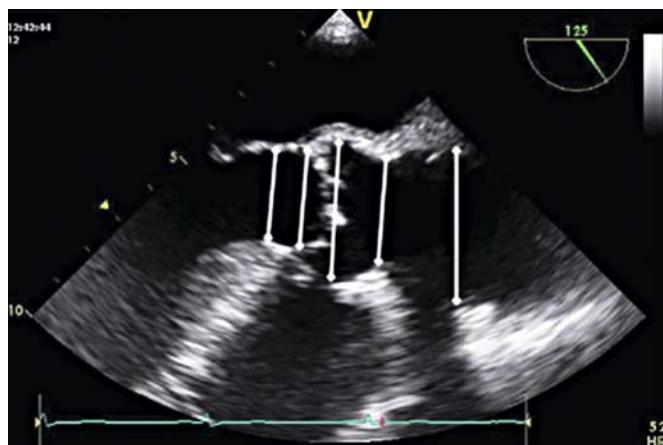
Intraoperative transesophageal echocardiographic measurements of the aortic valve annulus, including the diameter of the left ventricular outflow tract (to exclude severe asymmetric septal hypertrophy), aortic valve annulus, sinuses of Valsalva, sinotubular junction, and ascending aorta (arrows, from left to right). (From Pasic M, Buz S, Dreyssse S, et al. Transapical aortic valve implantation in 194 patients: problems, complications, and solutions. *Ann Thorac Surg*. 2010;90:1463–1469; discussion: 1469–1470.)
